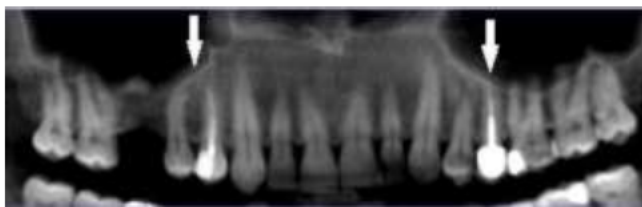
The shape of a panoramic image of CBCT shows an increase in the thickness of the mucosa in the maxillary sinuses. (Flash tip)
